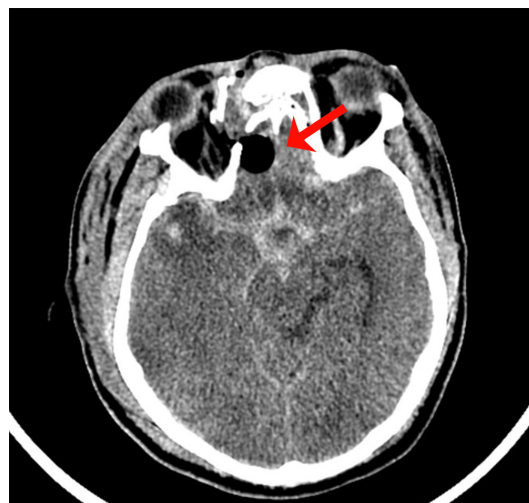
CT scan axial view showing the inflated Foley bulb, which was mistaken as pneumocephalus.
